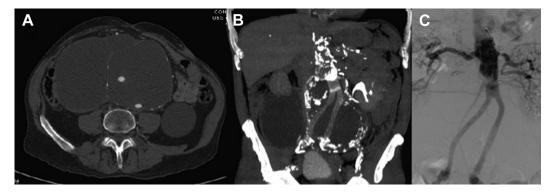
Panels (A) and (B) show primary diagnosis CT scan with severe proximal calcification. Panel (C) shows angiography with no endoleaks.
